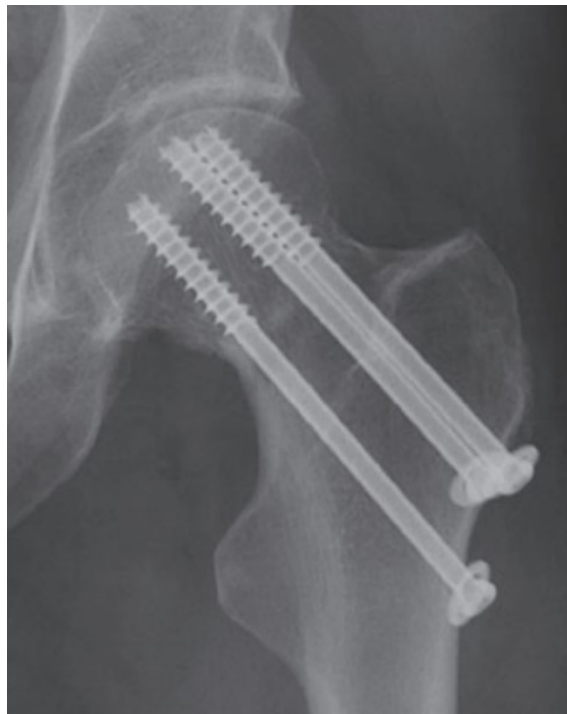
Radiograph of cannulated screws. Reproduced with permission from Springer (licence number: 4450960195677); [10].
